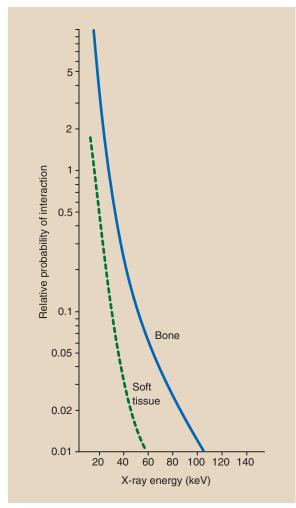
The relative probability that a given x-ray will undergo a photoelectric interaction is inversely proportional to the third power of the x-ray energy and directly proportional to the third power of the atomic number of the absorber.
